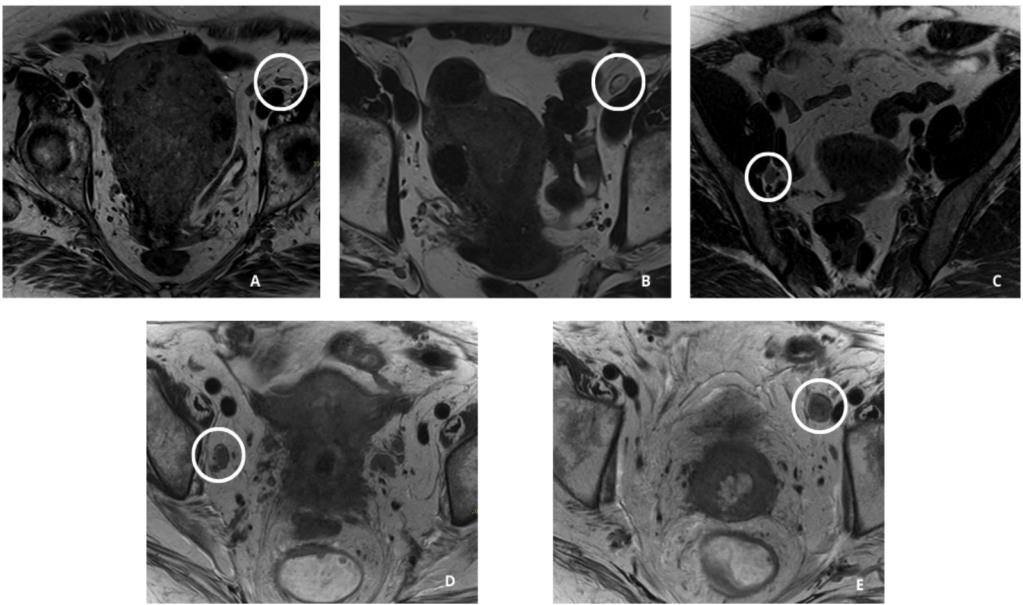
Axial T2-weighted MRI sequences of endometrial cancer patients showcasing pelvic lymph nodes with different Node-RADS scores. a Node- RADS 1: left external iliac LN with normal size and configuration. b Node-RADS 2: left external iliac LN showing a short axis of 5 mm and homogeneous signal intensity and fatty hilum. c Node-RADS 3: the right external iliac LN showing a short axis of 8 mm, spherical without fatty hilum, heterogenous signal intensity. d. Node-RADS 4: right obturator LN, 10 mm of short axis, heterogenous texture, irregular border. e. Node-RADS 5: left external iliac LN, 13 mm of short axis, spherical without fatty hilum with focal necrosis.
